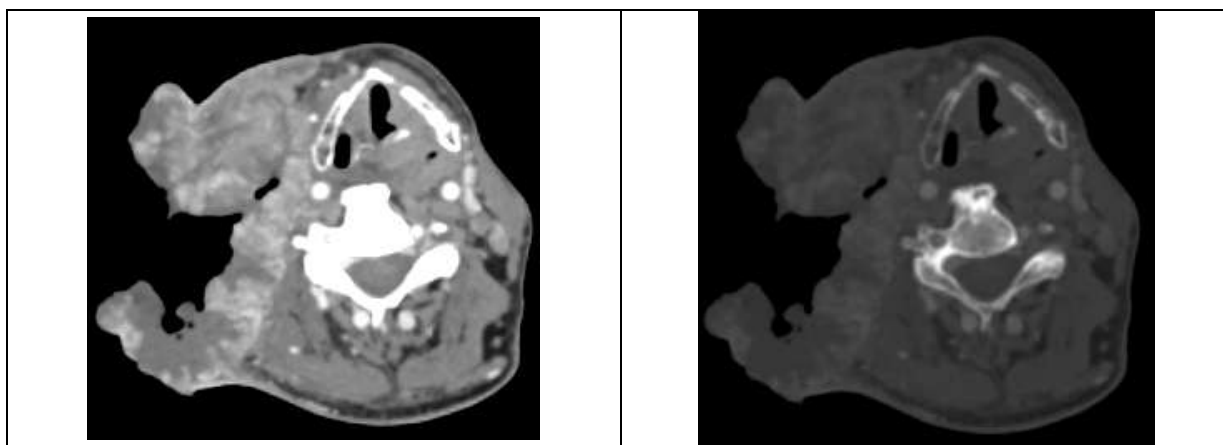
(a) and 5(b): Axial CECT and CT bone images at the level of thyroid cartilage in a case of Ca supraglottis shows sclerosis of left thyroid cartilage and a large necrotic conglomerated right cervical lymphodal deposit
